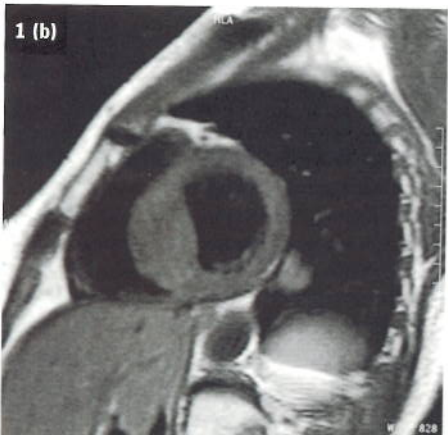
(a) TSE sequences which are triggered on every heart beat will produce static T1-weighted images of the heart in diastole. (b) T1-weighted TSE visualizes anatomy of the heart. (Courtesy of Cleveland Clinic, Cleveland, Ohio, USA)
